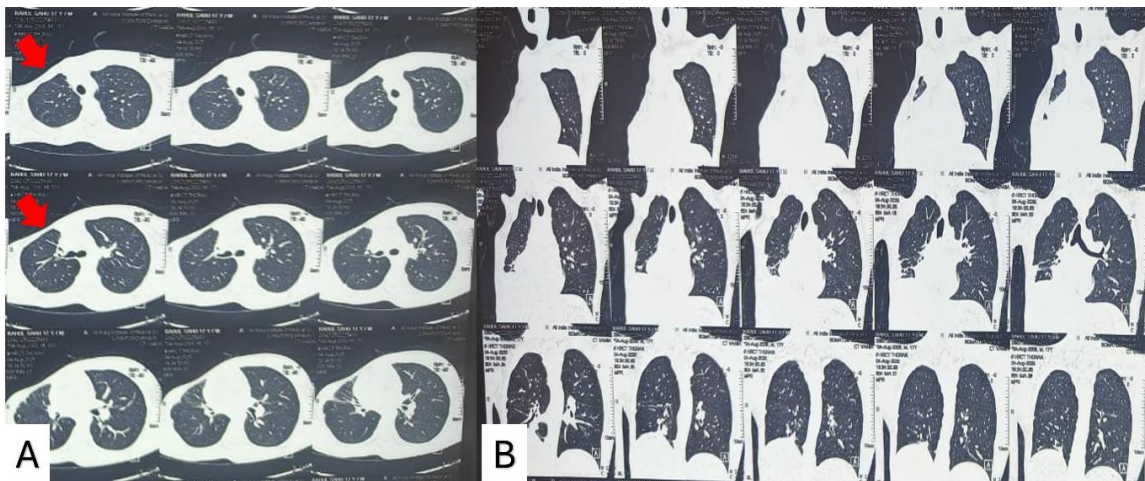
High-resolution computed tomography (HRCT) of the thorax.
